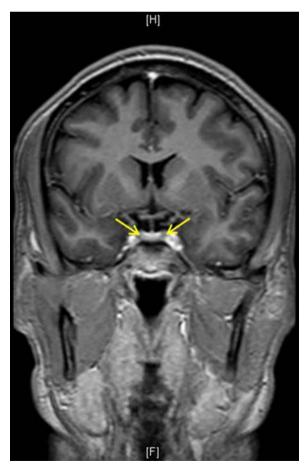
MRI of the brain showing a normal pituitary.
